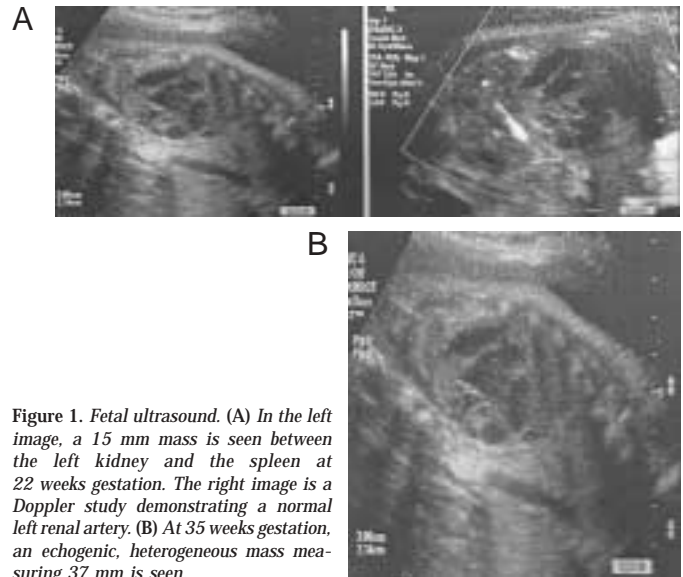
Fetal ultrasound. (A) In the left image, a 15 mm mass is seen between the left kidney and the spleen at 22 weeks gestation. The right image is a Doppler study demonstrating a normal left renal artery. (B) At 35 weeks gestation, an echogenic, heterogeneous mass measuring 37 mm is seen.
